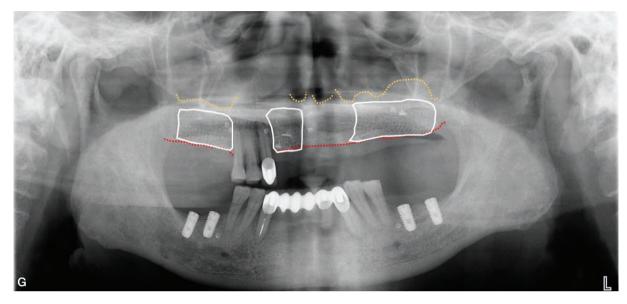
Maxillary sinus lift and GBR #16,17 (A,C,E). #12,22,23,25,26,27 (B,D,F) A~B: Bone defect before surgery C: Repair of bone defect using Allograft-PRF mixture D~E: Fixation of Ti-mesh with bone tack after repair with graft material F: Fixation with bone tack after applying an absorbable membrane on the Ti-mesh G: Panoramic radiograph after maxillary sinus lift and GBR
